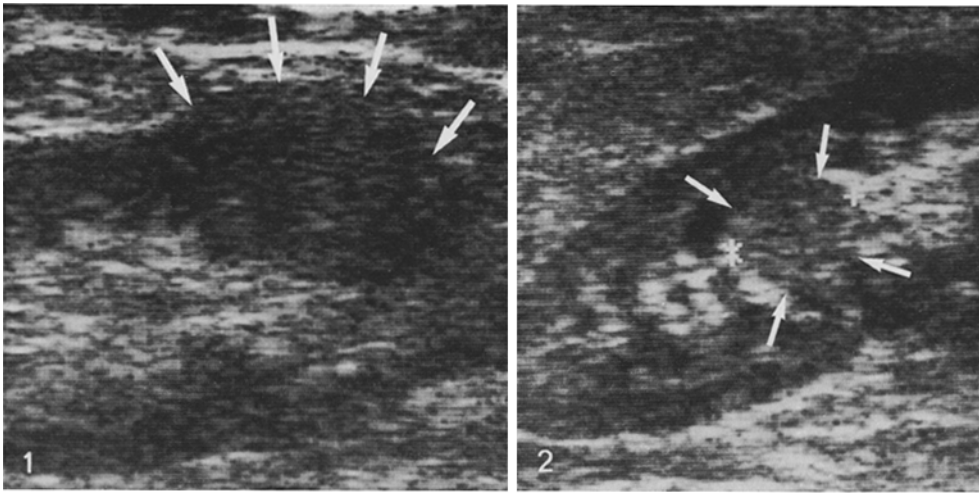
Longitudinal sonogram of a dromedary hump of the left kidney (*arrows*). No underlying parenchymal pathology
